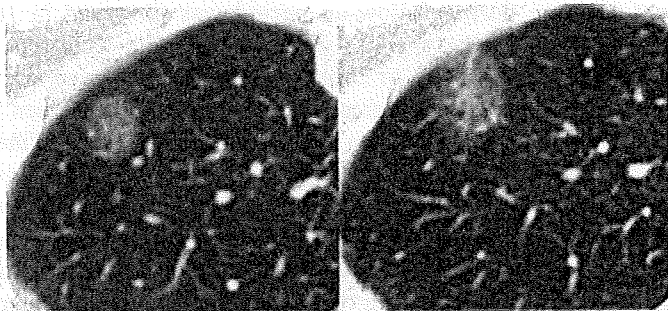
(Left: initial high-resolution computed tomography (HRCT); right: last HRCT; type 1 radiological finding) 66-year-old female, never smoker, 28-month interval; pure bronchioloalveolar carcinoma with del L747-T751.
